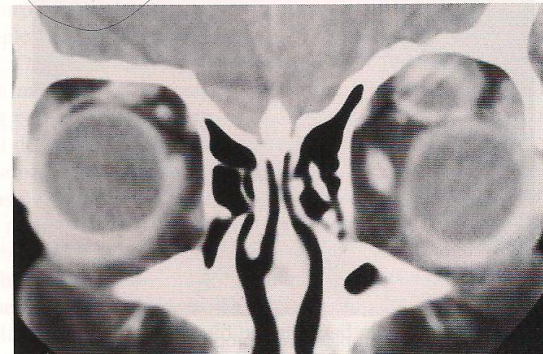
Coronal computed tomography showing superior orbital mass with cyst-like central portion.
